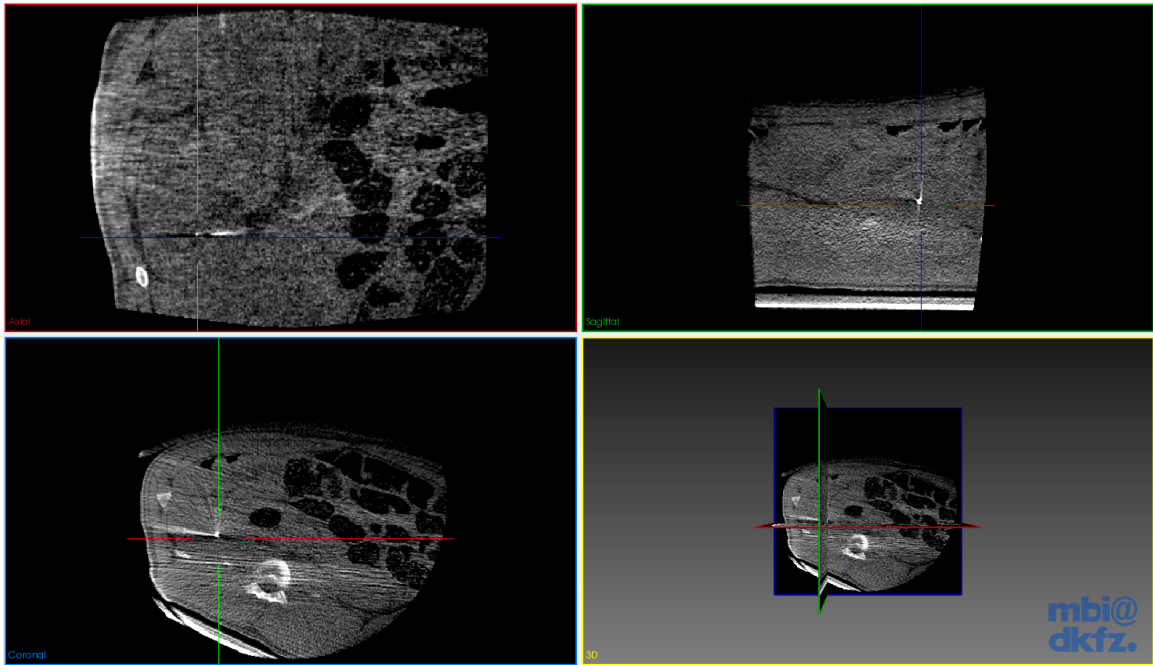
Perpendicular slices of a CT volume at the computed piezoelectric element position during *in vivo* experiment
